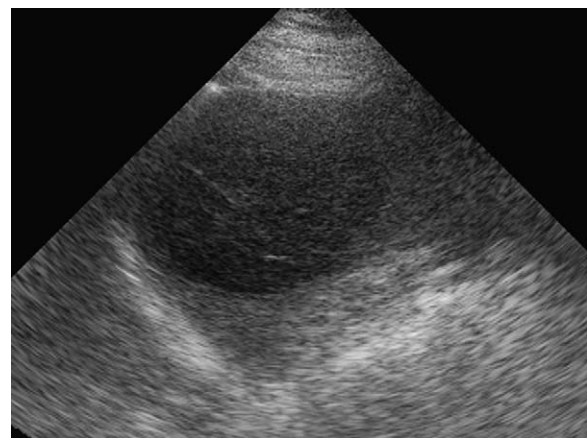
Amebic abscess. The ultrasound scan of the spleen shows a large hypoechoic mass in the upper pole.
